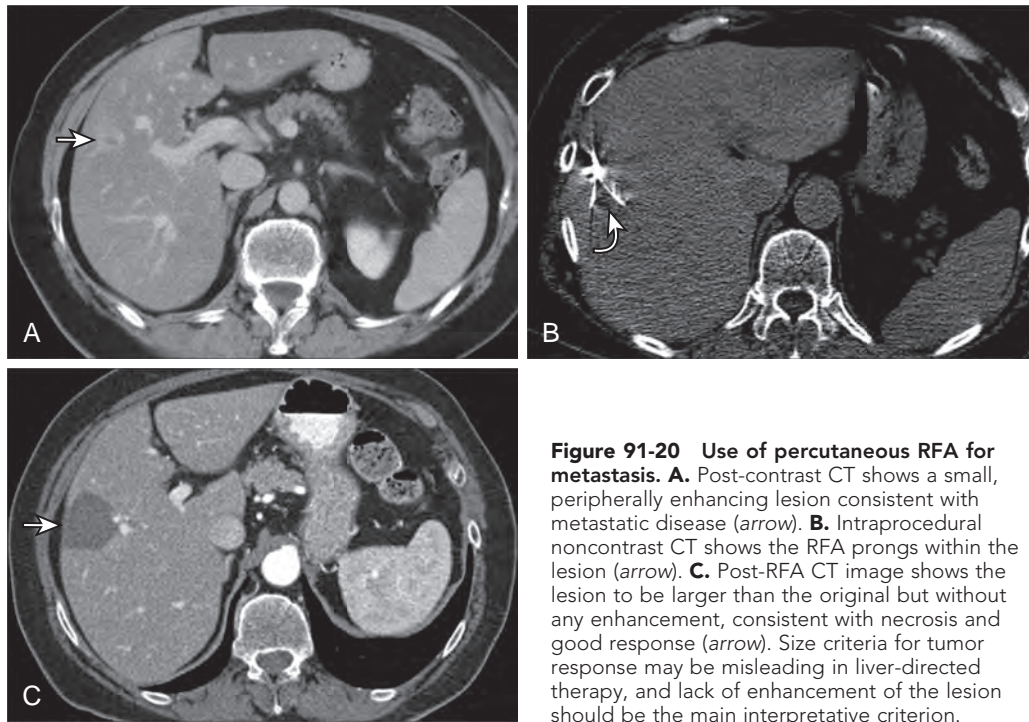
Use of percutaneous RFA for metastasis. A. Post-contrast CT shows a small, peripherally enhancing lesion consistent with metastatic disease (arrow). B. Intraprocedural noncontrast CT shows the RFA prongs within the lesion (arrow). C. Post-RFA CT image shows the lesion to be larger than the original but without any enhancement, consistent with necrosis and good response (arrow). Size criteria for tumor response may be misleading in liver-directed therapy, and lack of enhancement of the lesion should be the main interpretative criterion.
